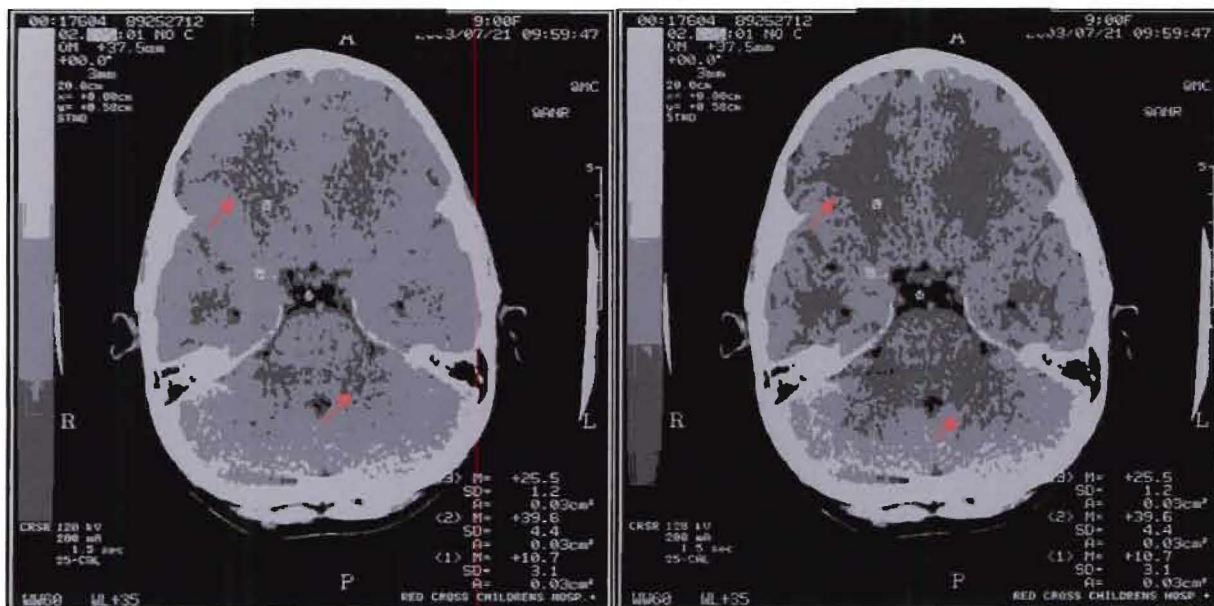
Showing two brain CT images that have been segmented using k-means clustering and fuzzy c-means clustering respectively
